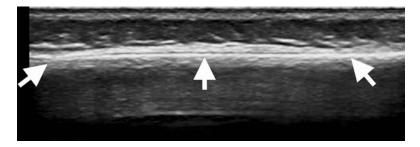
Ultrasound of the cortex bone demonstrated as a smooth echogenic line (*arrows*). There is no anatomical detail deep to this line as sound waves are reflected from the cortex
